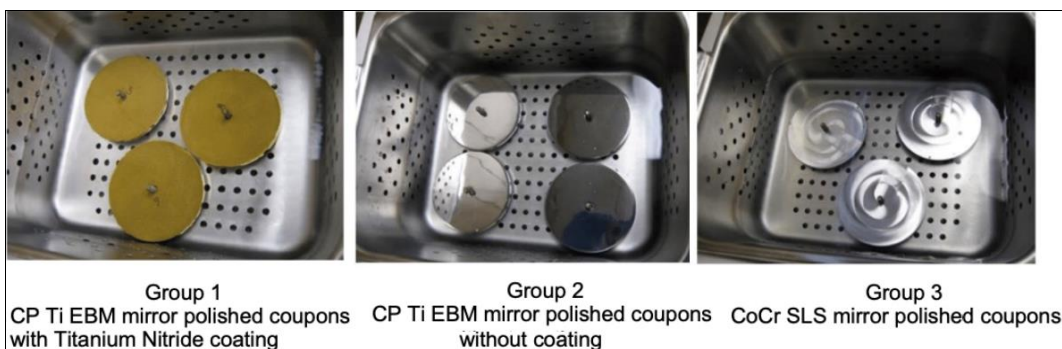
The ultrasonic cleaner setup with tested coupons are shown
